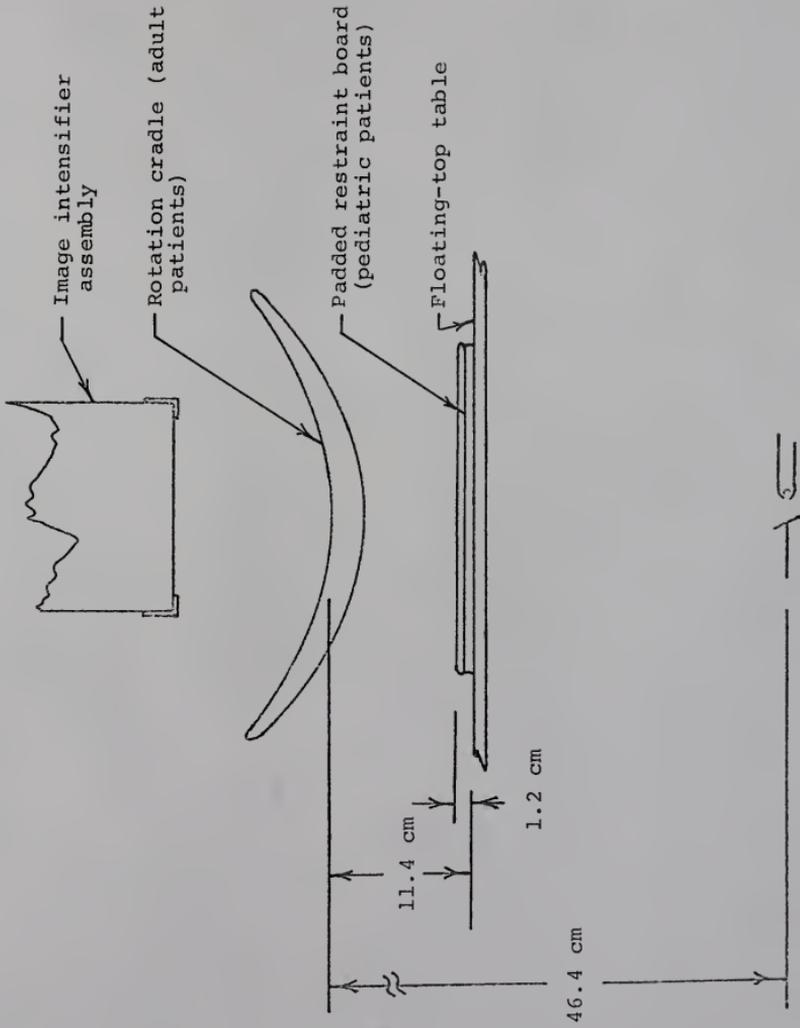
Dimensional Configuration for Under Table X-ray Source.
